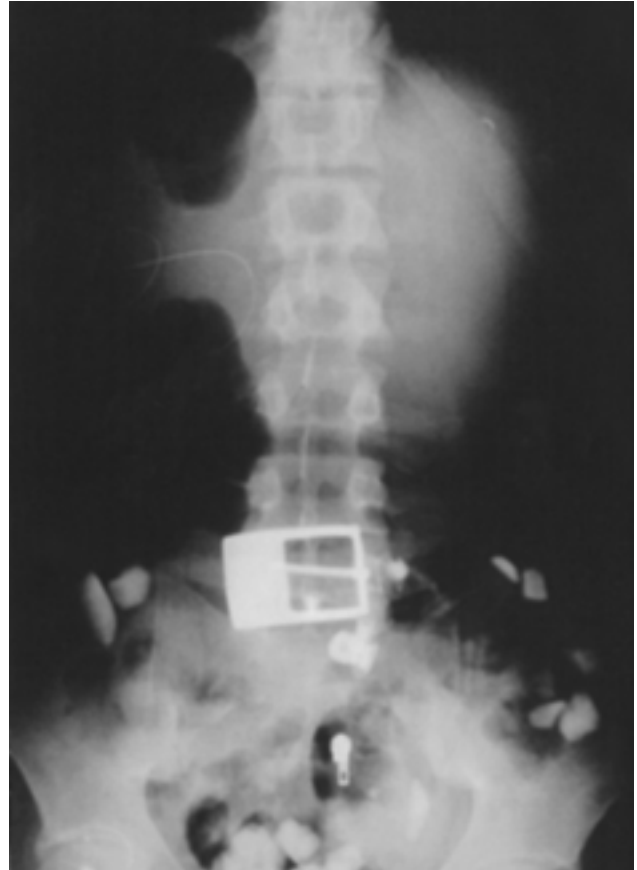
Direct abdominal radiograph
